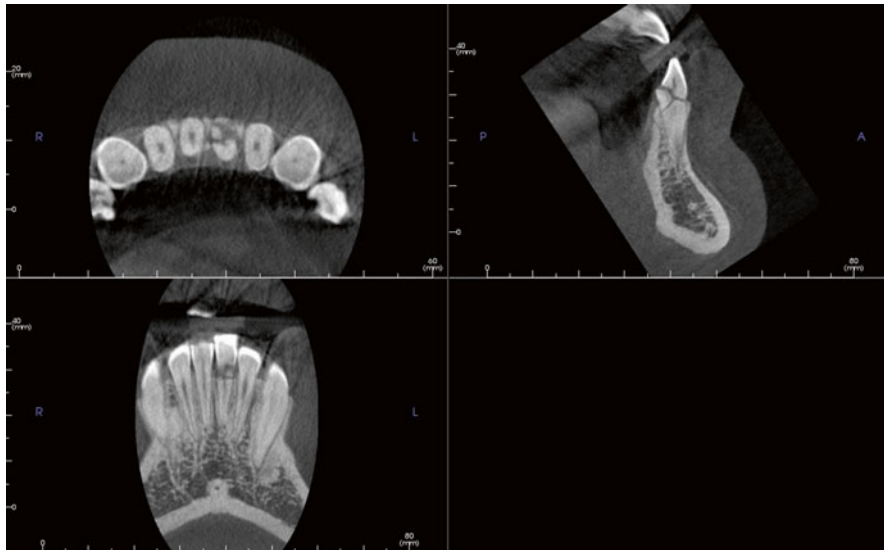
A 13-year-old male presented approximately 2 weeks after trauma to his mandibular anterior teeth that occurred while he was playing basketball. His primary concern was the looseness of tooth number 25. A CBCT scan was taken to evaluate the extent of the fracture. The original treatment plan (extraction) was modified after viewing the CBCT, since the buccal bone was very thin and likely to be lost during a surgical extraction. The treatment plan was changed to include root canal therapy, root submergence, and eventual slow extrusion of the tooth to maintain bone for a future implant
